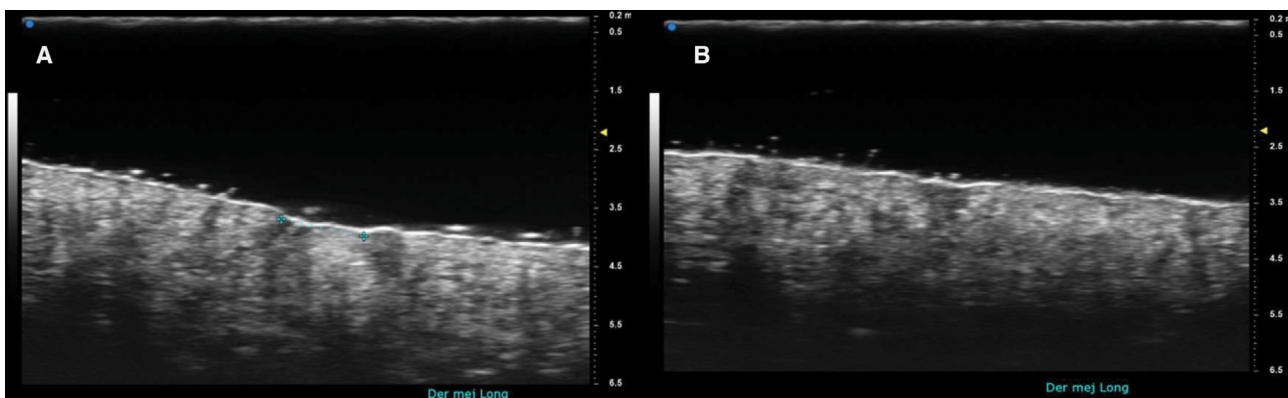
Ultra-high-frequency ultrasound (70 MHz; greyscale) of a scar (epidermal depression) treated with a CO2 laser (longitudinal diameter): (A) Baseline: 1.4 mm. (B) Follow-up at 3 months: 1.3 mm.
